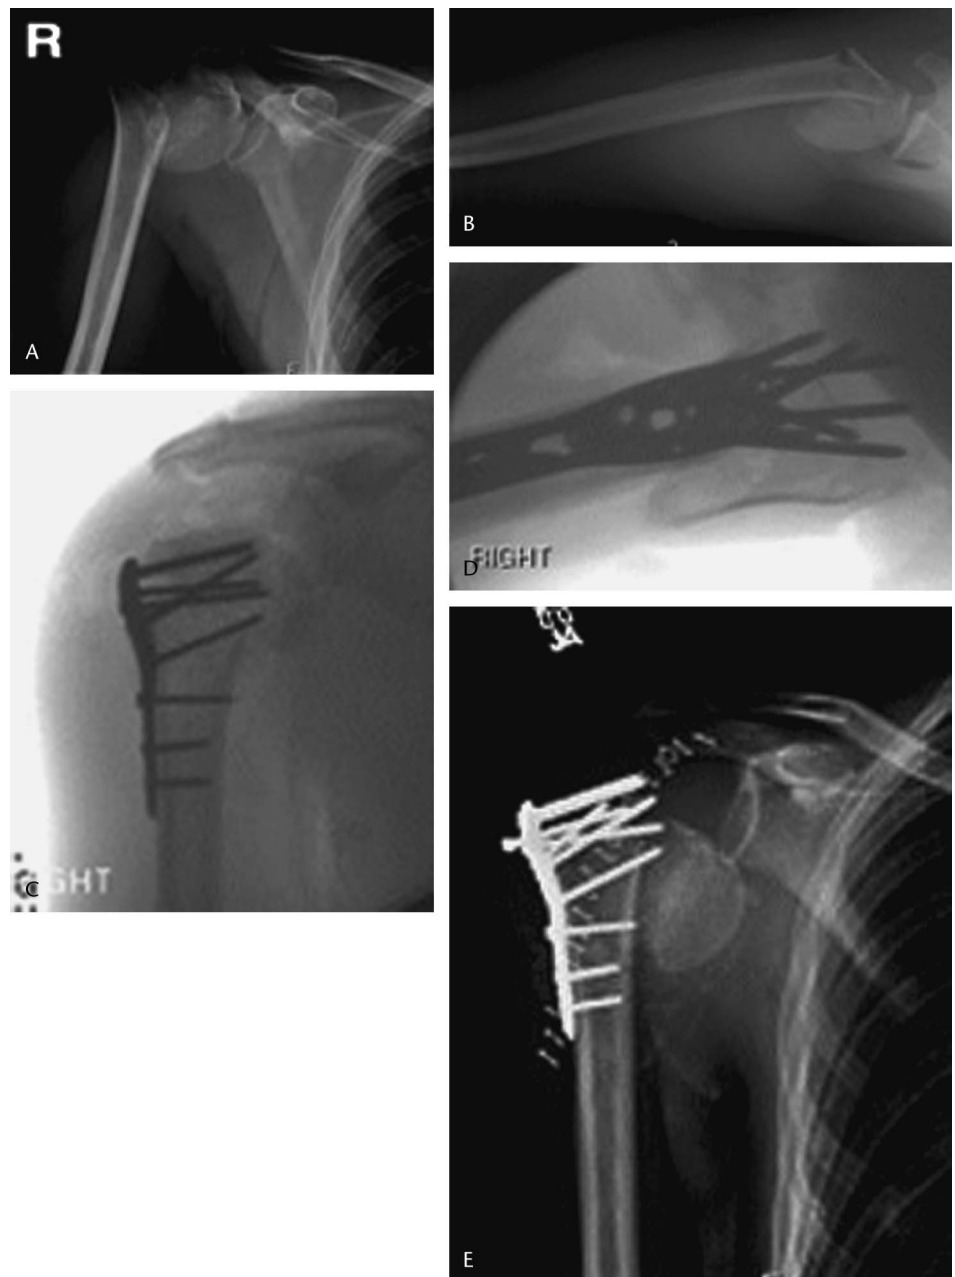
Example of construct pullout that occurred in a 55-year-old man who sustained a right 2-part proximal humerus fracture after a fall from a standing height as seen on the (A) anteroposterior and (B) axillary views. Intraoperative (C) anteroposterior and (D) axillary views demonstrate fracture fixation performed with a proximal humerus locking plate that included 6 screws in the humeral head. At the 6-week follow-up visit, the patient reported pain in his right shoulder. As seen on the (E) anteroposterior x-ray, implant failure occurred with construct pullout from the humeral head. In this case, poor bone stock and inadequate screw purchase in the humeral head did not provide enough bony fixation to absorb the bending and torsional loads associated with early range of motion exercises. Placement of additional screws peripheral to the plate to augment the fixation provided by the locked plate may have avoided the development of this complication.
